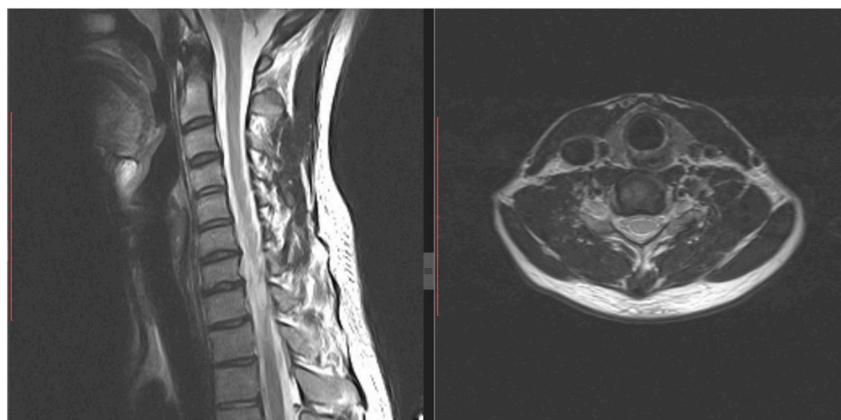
A/B MRI radiograph displaying disc herniation at C6–C7 and C7–T1. A. Sagittal view B. Axial. View. C6–7 being the more affected level.
